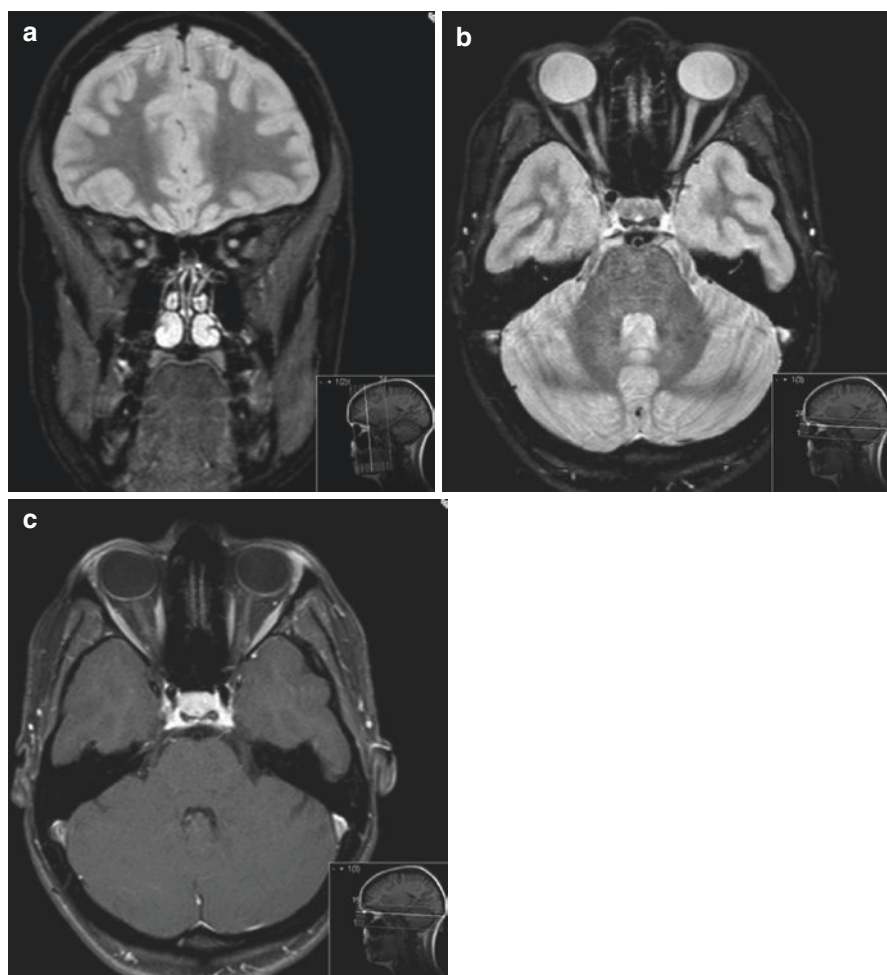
MRI: coronal (a) and axial (b) T2 weighted scan of the optic nerves showing high signal on both sides, and (c) axial T1 weighted scan following administration of contrast showing minor enhancement of the right optic nerve
